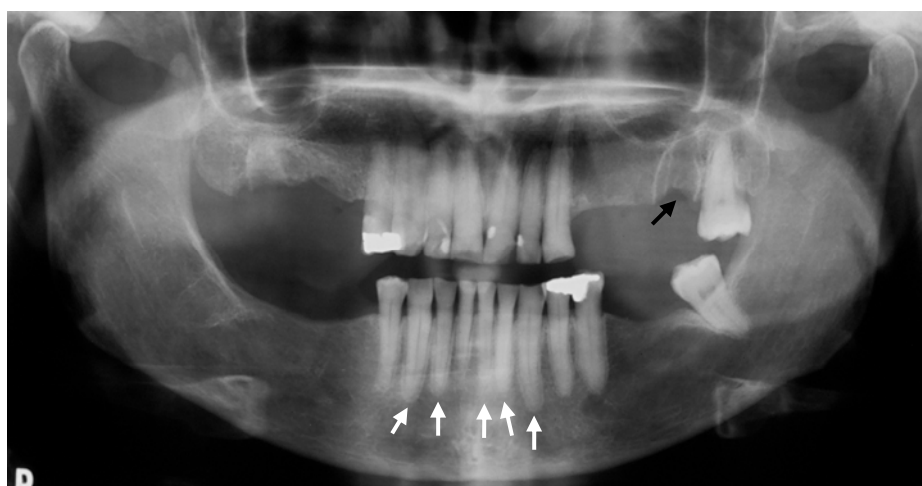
Panoramic radiograph from a female patient under pamidronate therapy, who developed osteonecrosis after extraction of 2<sup>nd</sup> upper left molar. The black arrow shows osteolytic area in left maxilla; white arrows show sclerosis of lamina dura in lower teeth.
